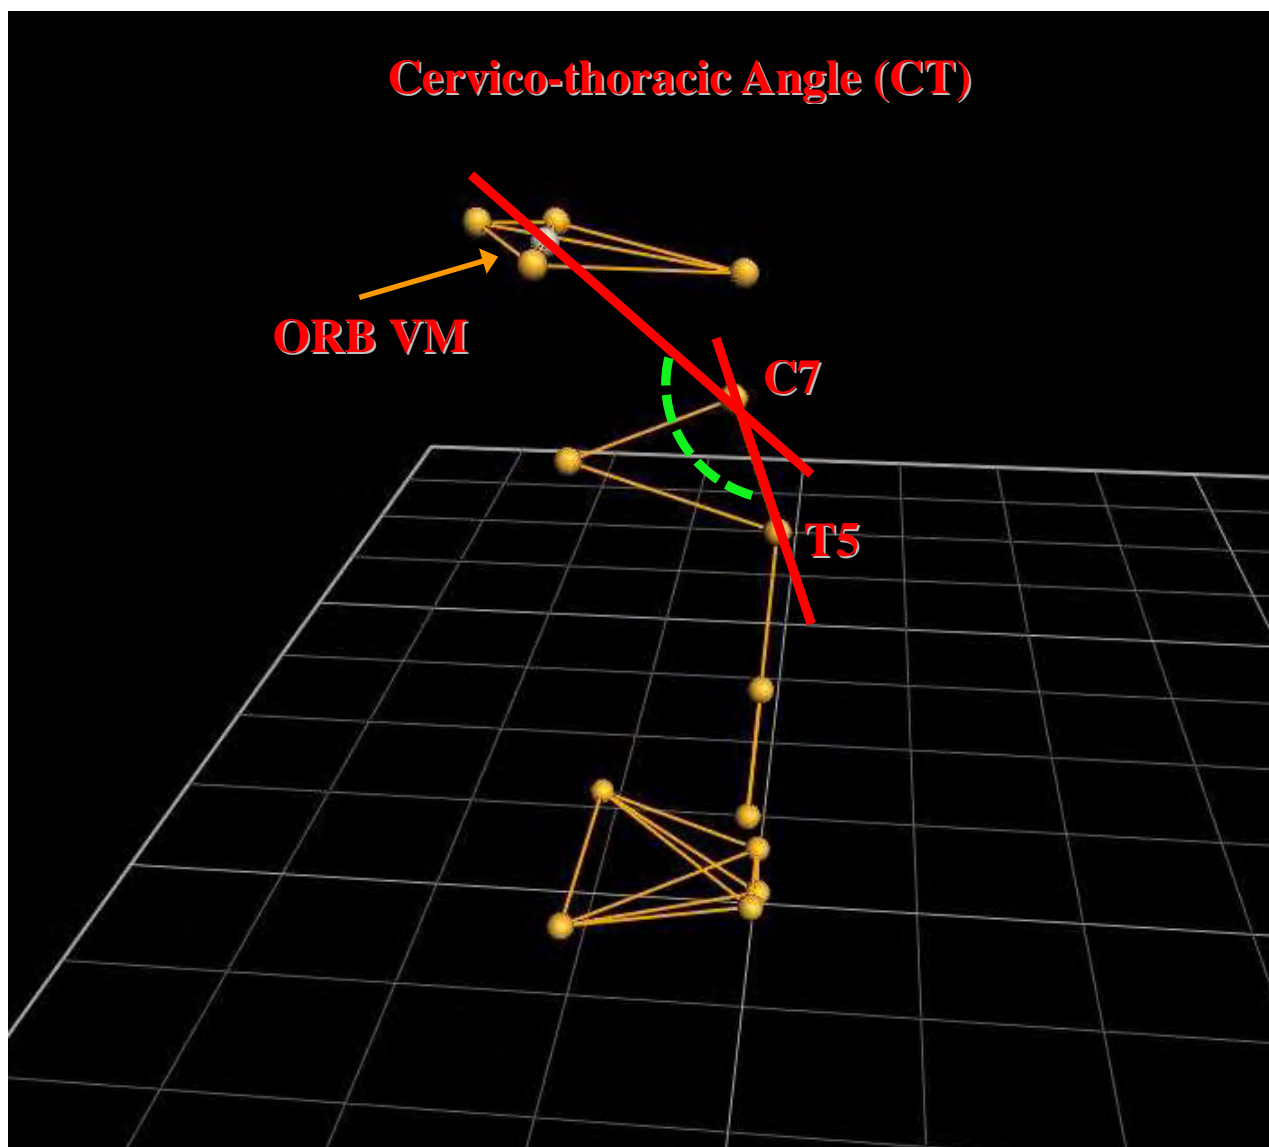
Representation of the Cervico-thoracic angle (CT) as is formed among markers.
